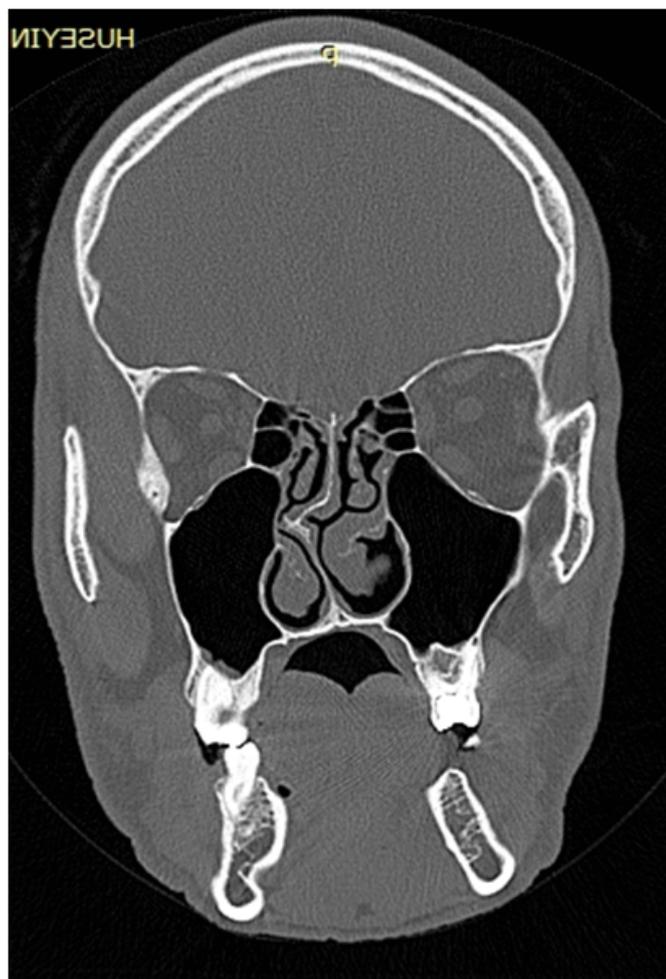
Follow-up coronal computed tomography image.
